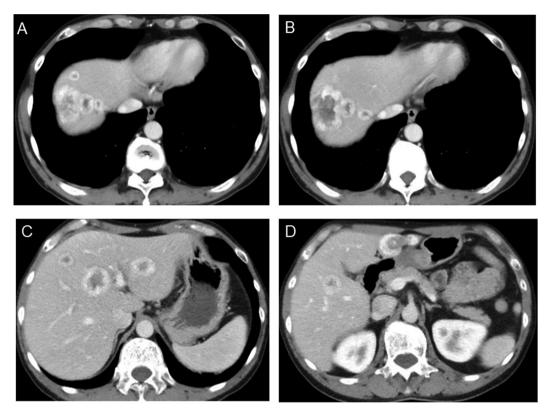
Contrast-enhanced computed tomography before the first hepatectomy. Cranial to caudal slice (A-D). All metastatic tumors decreased in size with obvious calcification after induction of chemotherapy. No new obvious lesion was observed.
